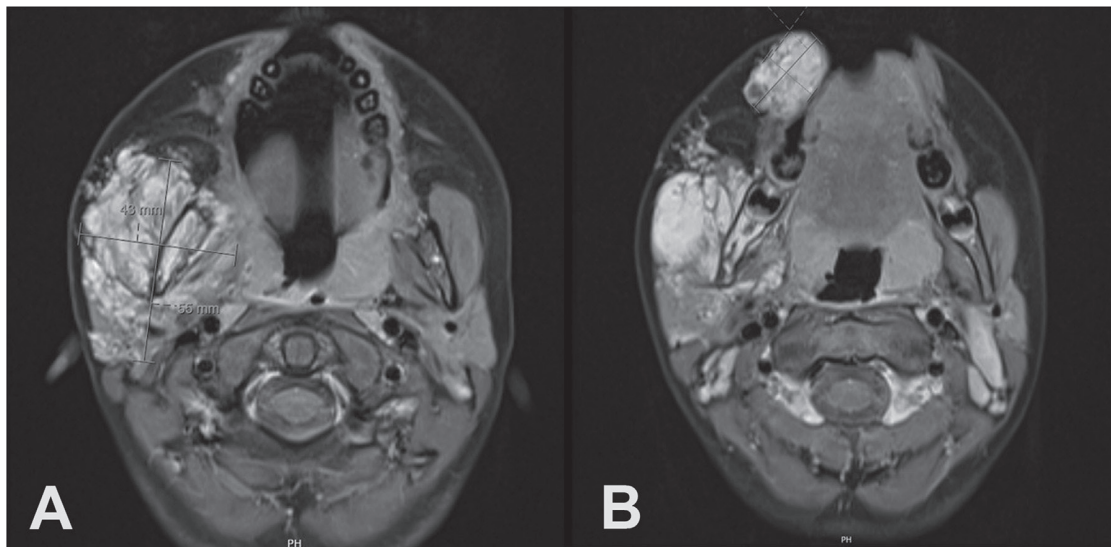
(A and B) Magnetic resonance imaging (T1-weighted), when the patient was 6 years old, showed a right facial mass measuring approximately 5.5 cm in greatest dimension and involving the right medial pterygoid muscle, right pterygoid fossa laterally, and the right masseter muscle and buccal space anteriorly. Compression on the right palatine tonsil caused mild airway narrowing.
